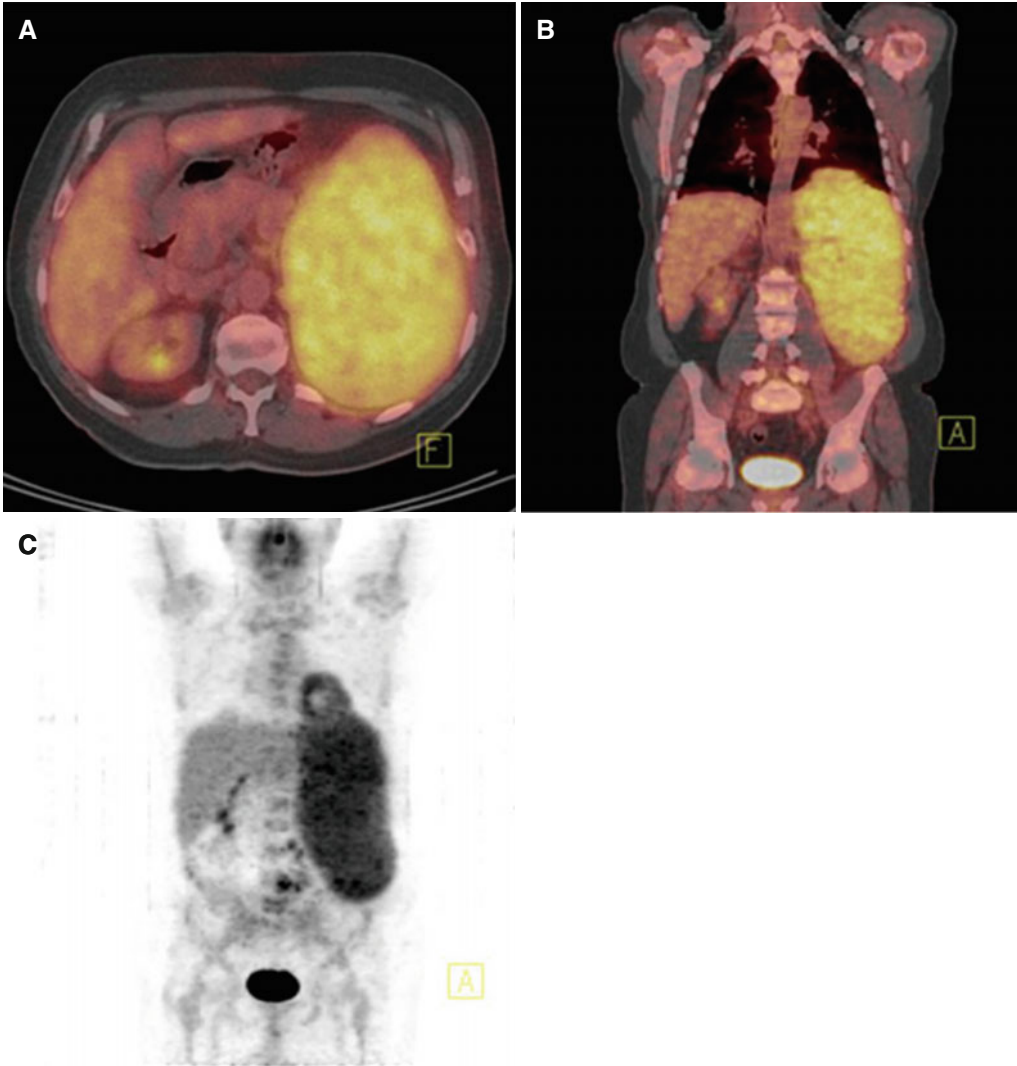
Axial and coronal PET/CT images (A, B) and PET MIP image (C) show enlarged spleen and diffuse uptake of FDG from the splenic parenchyma (SUV_{max} 5.5)
